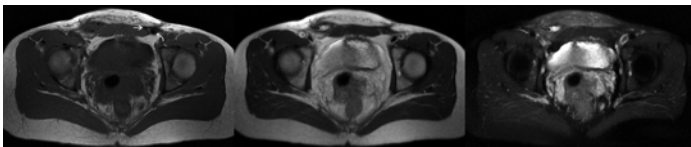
Axial MR T1-weighted, T2-weighted, and fat-saturated T2-weighted images of bilateral flat mesh repairs. The normal mesh on the *left* (*white arrow*) appears smooth and linear, particularly on T1. Dark “blooming” artifacts (*curved white arrow*) are commonly encountered in the postoperative groin and are due to the presence of metal tacks or staples. In comparison, the mesh on the *right* is distorted and difficult to visualize (*black arrow*) due to mesh infection. There is a large fluid collection (*curved black arrows*) just posterior to mesh material, best visualized on the fluid-sensitive T2 sequences.
